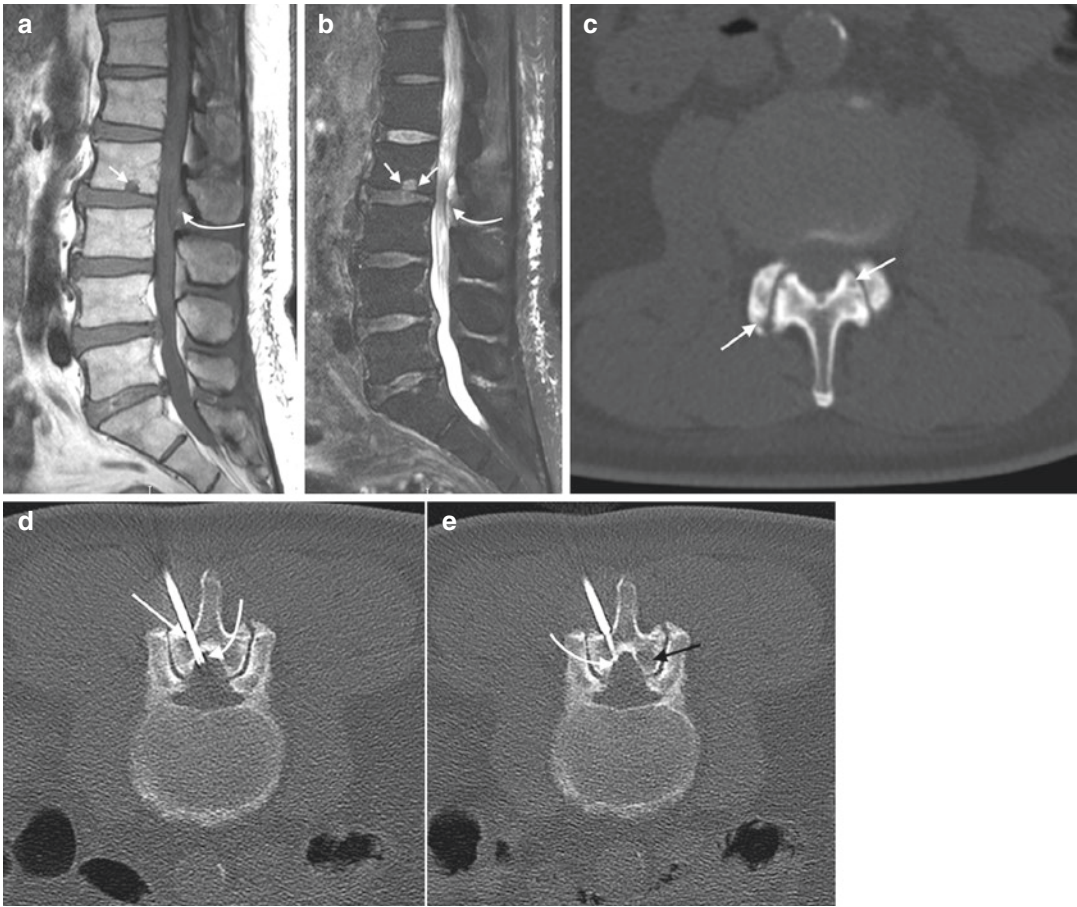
A 72-year-old male with prior history of diabetes, chronic renal failure, and gout presents with severe, crippling back pain. An elevated ESR (83), CRP (32.8), and WBC (12.1) were noted at the time of clinical presentation. A T1-weighted sagittal image (a) shows a subtle hypointense dorsal epidural collection at L2–L3 (*curved arrow*). What appears to be Schmorl's node (*arrow*) involves the inferior endplate of L2. The epidural fluid collection (*curved arrow*) is hyperintense on the T2 sagittal image (b). The small round hyperintense focus within the inferior endplate of L2 (*small arrows*) appears separate from the adjacent disk and may not be Schmorl's node. Axial CT image (c) in bone window algorithm at
